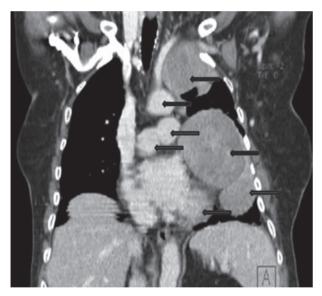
Computed tomography of the chest – multifocal tumors in the whole left hemithorax (vertical).
